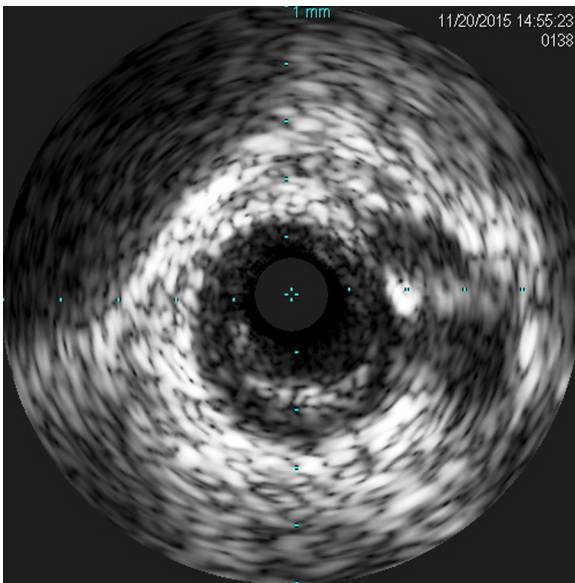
Intravascular ultrasound (IVUS) of the proximal cap of the LAD CTO imaged from the native diagonal artery bifurcation.
